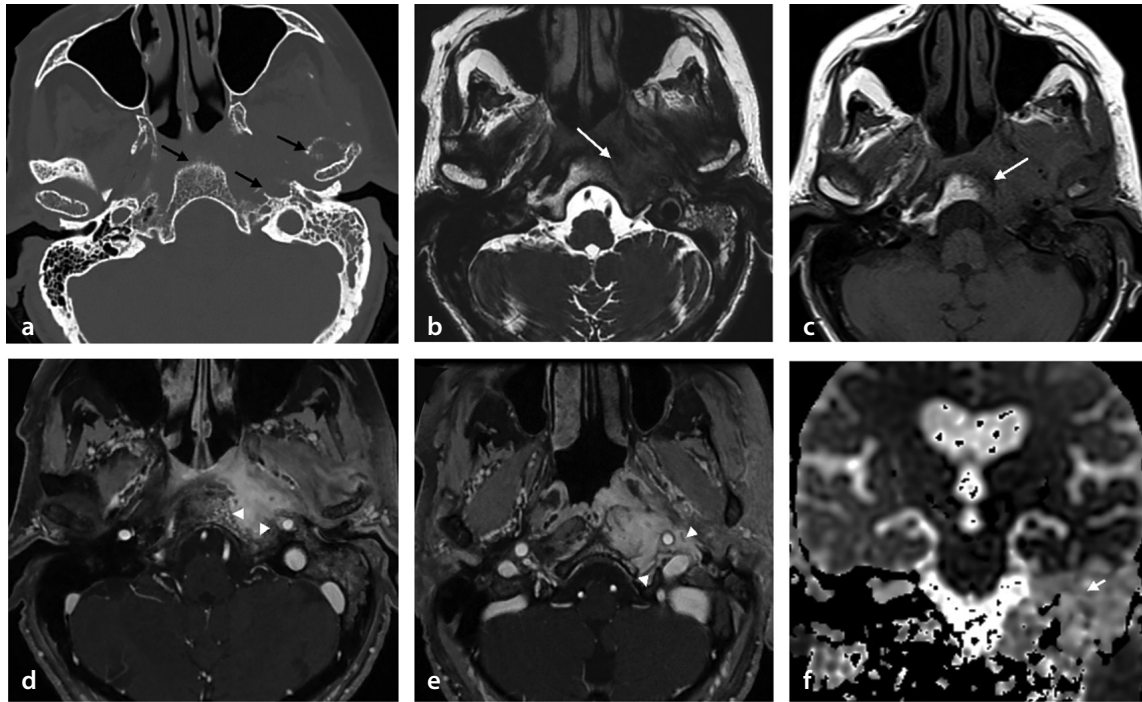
Imaging findings consistent with necrotizing otitis externa and skull base osteomyelitis in a 67-year-old female patient with a history of diabetes mellitus, presenting with prolonged severe ear pain. Computed tomography (a) reveals opacification in the mastoid and middle ear, along with erosion of the clivus, mandibular condyle, and temporal bone (black arrows). Axial heavily T2-weighted image (b) demonstrates slight hyperintensity, and non-fat-saturated T1-weighted (T1W) images (c) reveal reduced bone marrow signal (white arrow). Post-contrast fat-saturated T1W images (d, e) reveal clival invasion with extension into the pharyngeal mucosal area, parapharyngeal, and carotid space (arrowheads). The apparent diffusion coefficient (ADC) map (f) demonstrates hyperintensity and high ADC values (small arrow). The patient's ear culture grew *Pseudomonas aeruginosa*, and intravenous treatment is ongoing.
